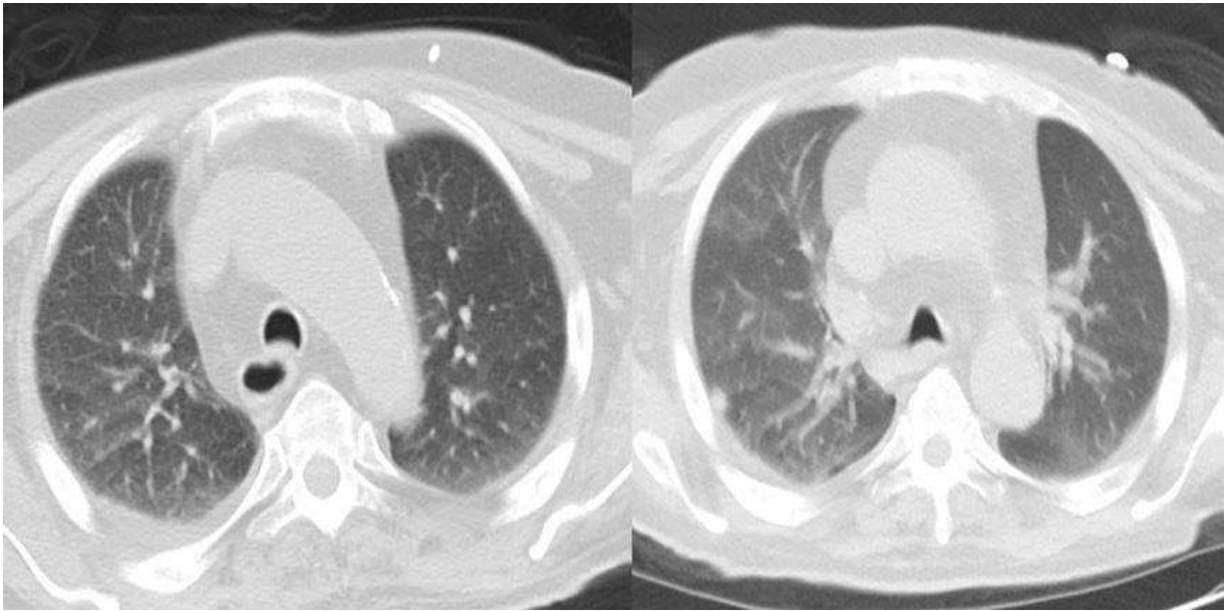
Thorax CT image at control examination.
